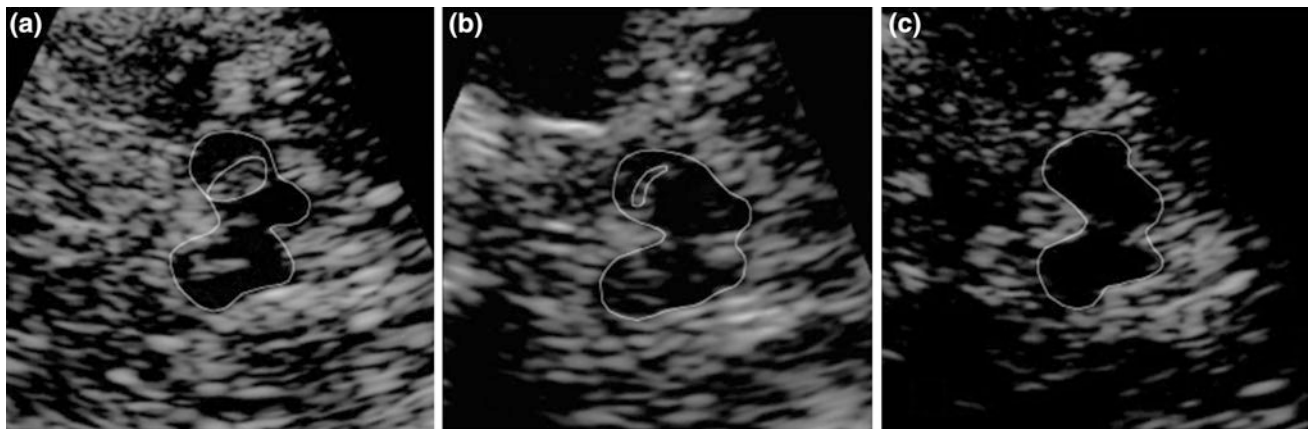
Transcranial ultrasound images (axial plane) in three patients. a Patient with Parkinson's disease (PD). b Control subject. c Patient with restless legs syndrome (RLS). Midbrain is *encircled* and areas of hyperechogenicity are *encircled* in (a) and (b). There is a
